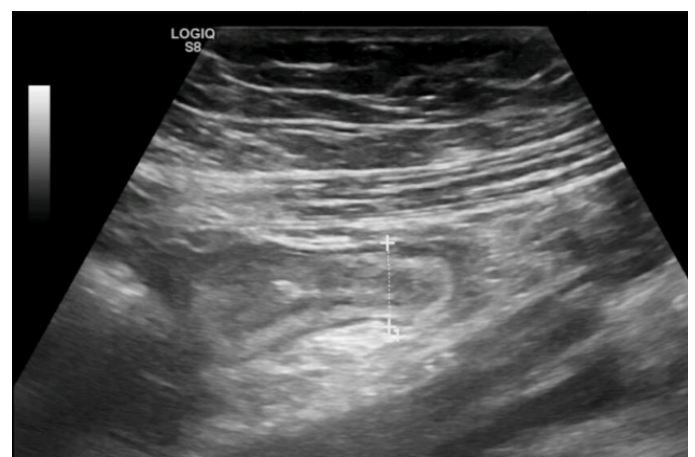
Abdominal ultrasound revealed edematous wall thickening of appendix with distended appendicular lumen showing wide caliber 12 mm.
